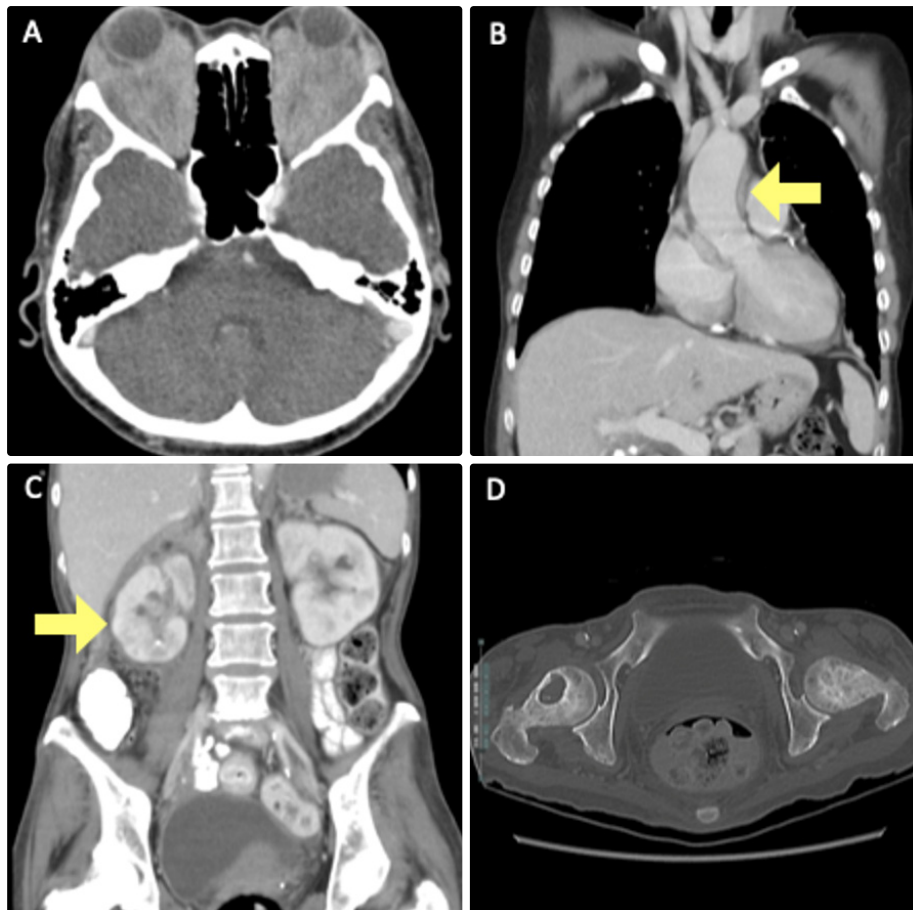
Computed tomography demonstrates (A) bilateral retroorbital soft tissue causing proptosis, (B) soft tissue thickening along the aortic arch, (C) soft tissue thickening along the walls of the bilateral pelvicalyceal systems, and (D) deffuse sclerosis of the proximal femurs.
